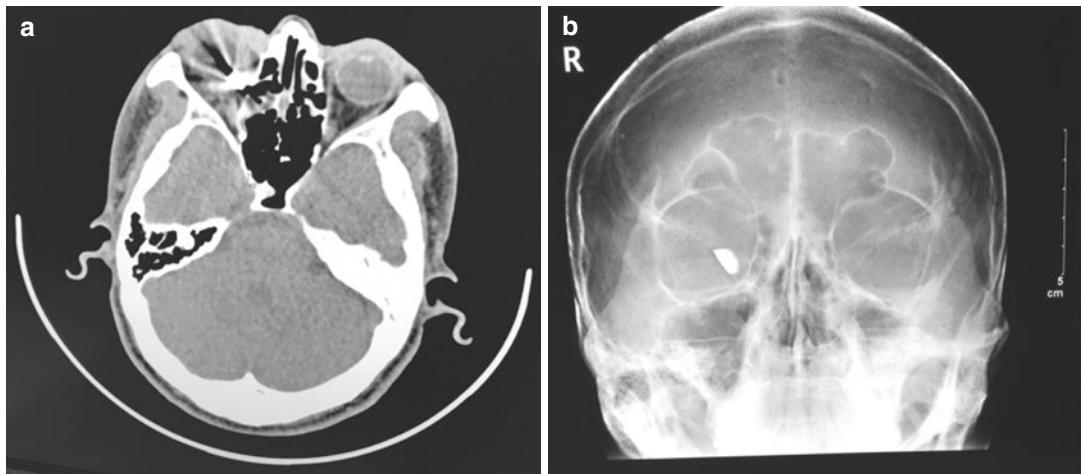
Orbital CT (a) and X-ray (b) showing the right eye has perforating injury, with high-density foreign body in the ball, about 9.68×5.69 mm
